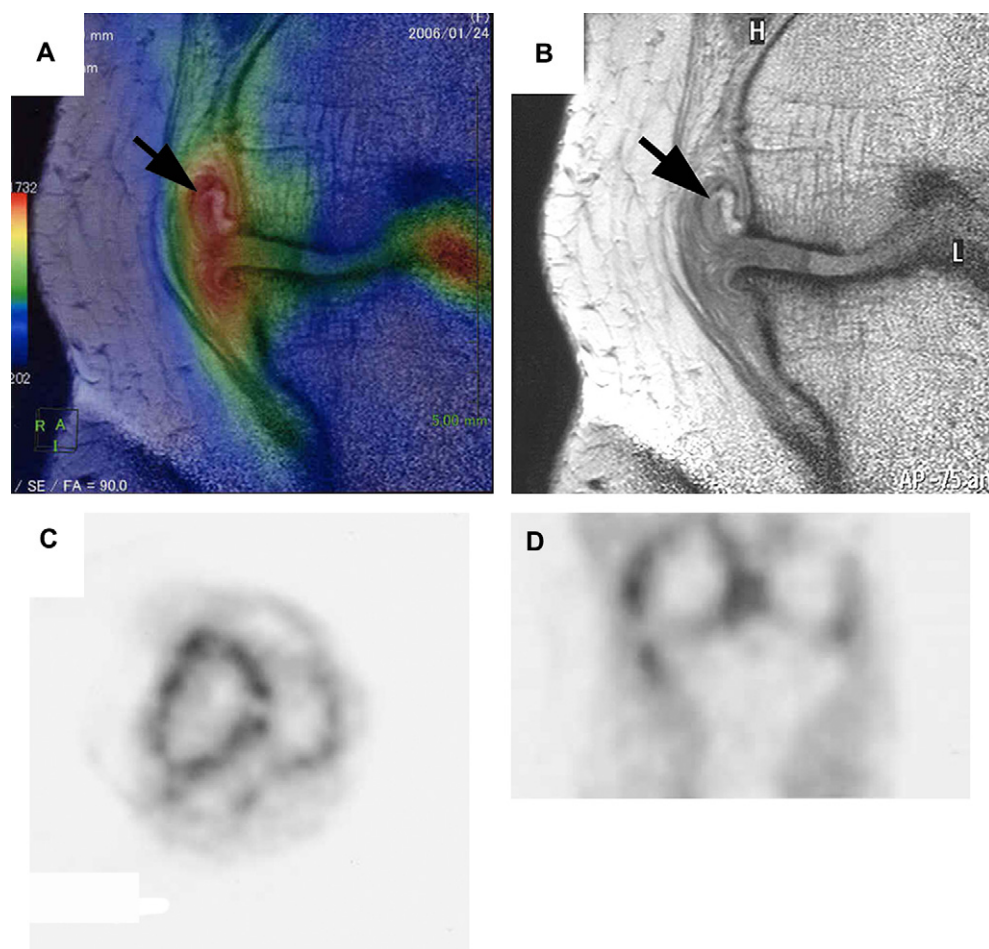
$^{18}\text{F}$ -FDG accumulation was found around medial osteophyte (Arrow). (A) Fusion image, (B) MRI, (C) PET axial view, and (D) PET coronal view.
